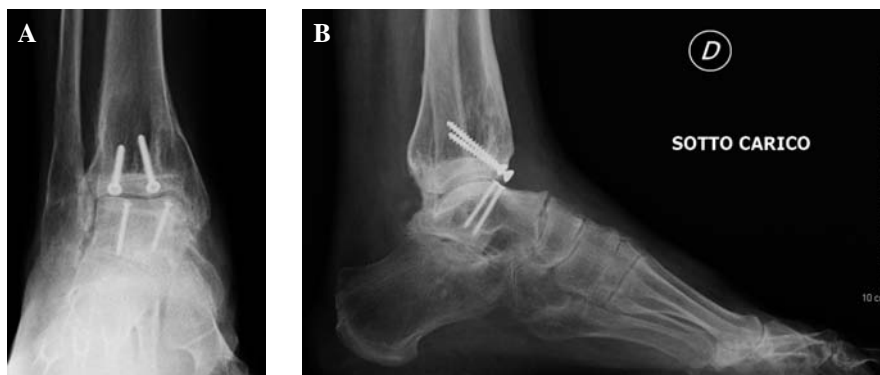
Followup AP (A) and lateral (B) X-rays showing complete integration of the allograft.
